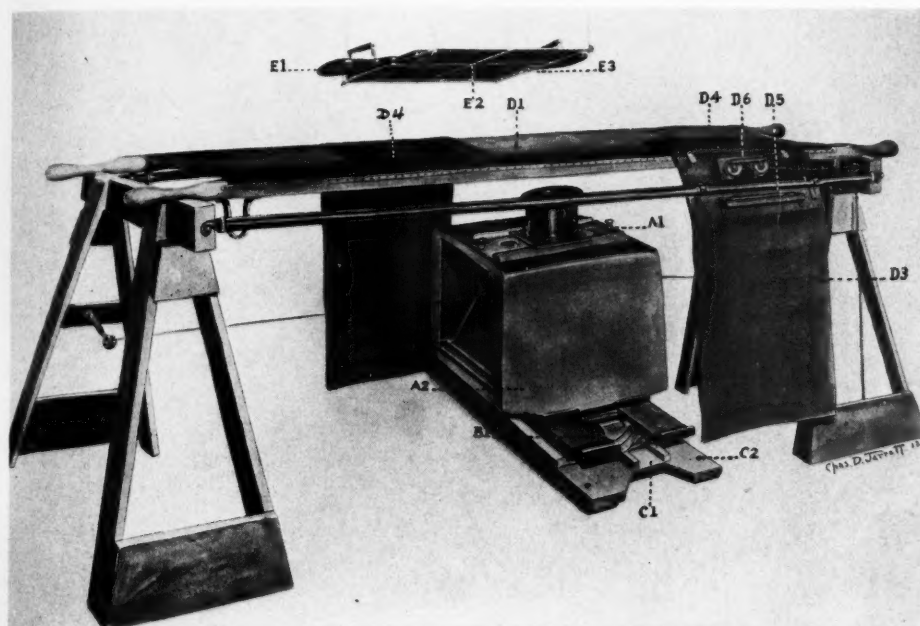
Combination fluoroscopic, radiographic, and foreign body localization apparatus. Diaphragm openings of portable x-ray tube holder, A1. Left foot insert, C1. Lead sheeting, A2. Upper half of 10-cm. displacement apparatus, B1. Movable lead rubber apron, D3. Double throw switch for lights and fluoroscopic current, D6. Skin marking shelf, pencil, and ink, D5. Accessory flexible lead rubber protection flap, D4. Fluoroscopic screen, E1. Direct reading localization scale in centimeters upon fluorescent screen, E3.
